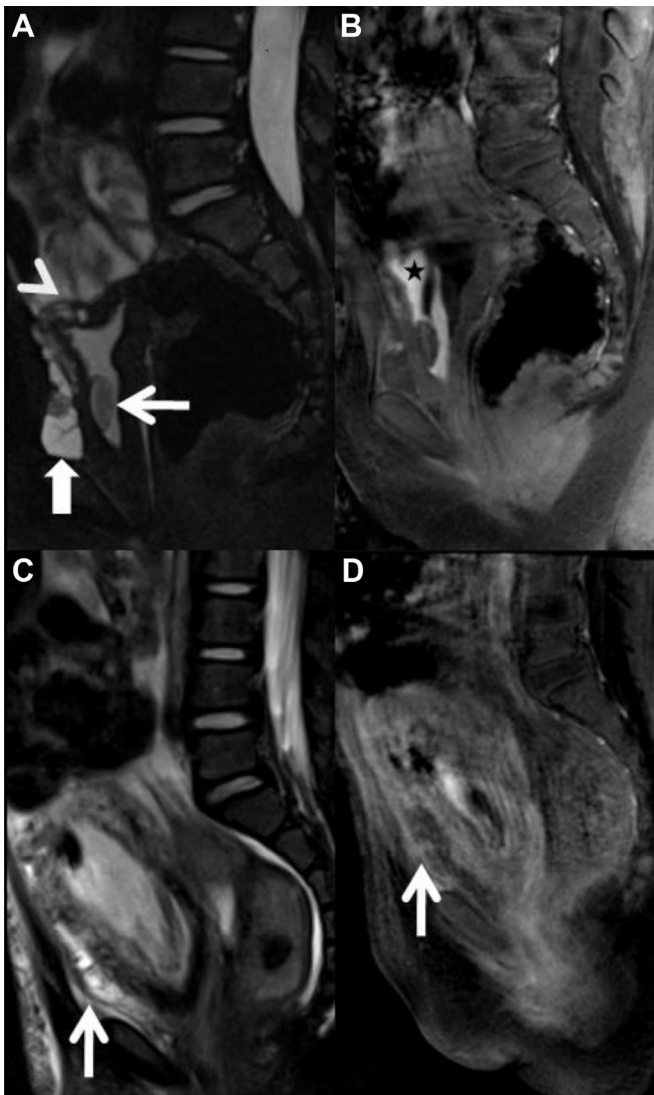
3-year-old-girl with history of a bladder vascular malformation had undergone MRI of the pelvis for further characterization; (A) sagittal T2 fat-saturated image shows a lobulated predominantly hyperintense lesions adherent to the anterior bladder (block arrow), intraluminal (arrow) and intramural (arrowhead) in location; (B) sagittal T1-post contrast image shows no significant enhancement of the three components and gadolinium contrast in the bladder (black asterisk), findings consistent with a lymphatic malformation. MRI of the pelvis performed status-post partial sodium tetradecyl sulfate embolization and clinical presentation of hematuria; (C) sagittal T2 fat-saturated image shows decrease in size of extrinsic lobulated component (arrow) and stable appearance of intramural component; (D) sagittal T1-post contrast image shows no enhancement (arrow), again confirming the imaging features of a lymphatic malformation.
